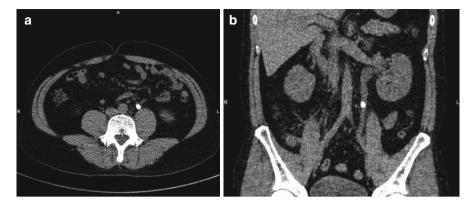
Native CT scan of a 43-year-old male patient showing an impacted 7 mm stone in the ureter on the left-hand side. (a) Transverse plane; (b) Coronal plane
